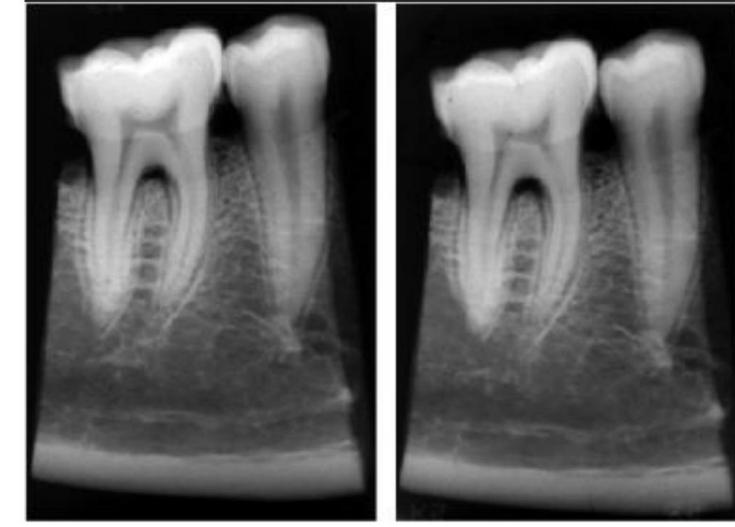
Radiographs before and after bone was removed.
